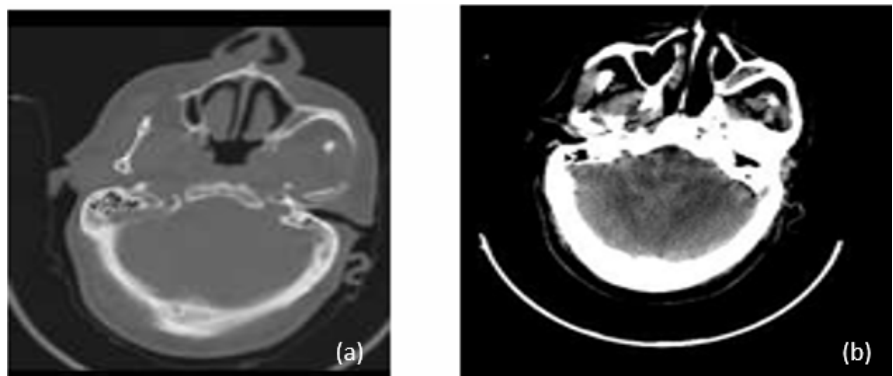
CT scan of the brain with a bone window shows no widening of the right internal auditory canal.
